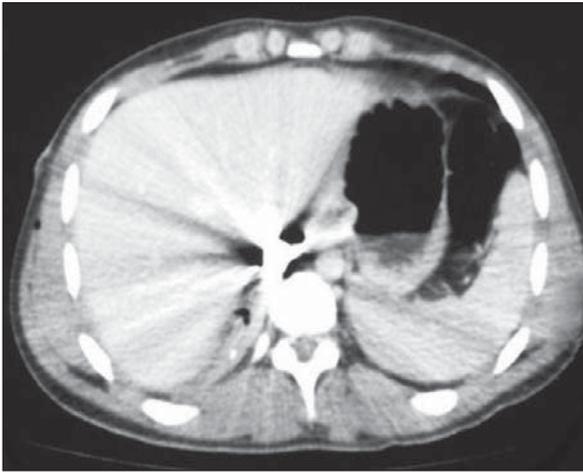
Abdominal CT slice showing the close proximity of the fragmented bullet to the IVC.
